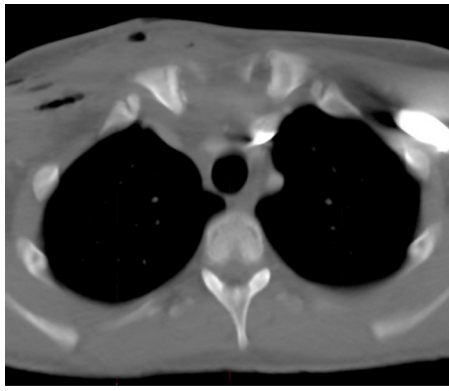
Axial view of the superior chest CT scan on day 2 after surgery showed a complete reduction of the epiphyseal fracture.
